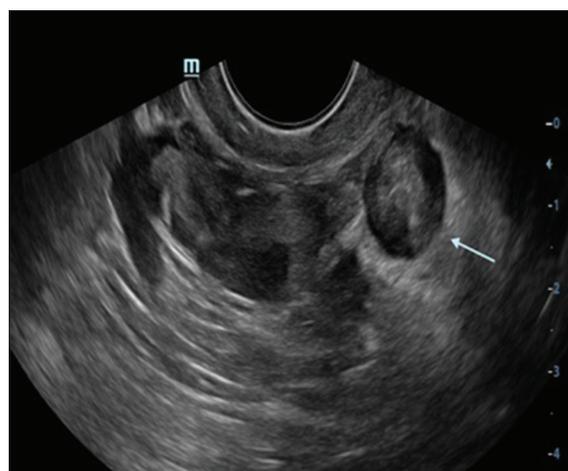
Transperineal ultrasound showing isoechoic mass lesion arising from right vaginal wall near anal sphincter (arrow)
